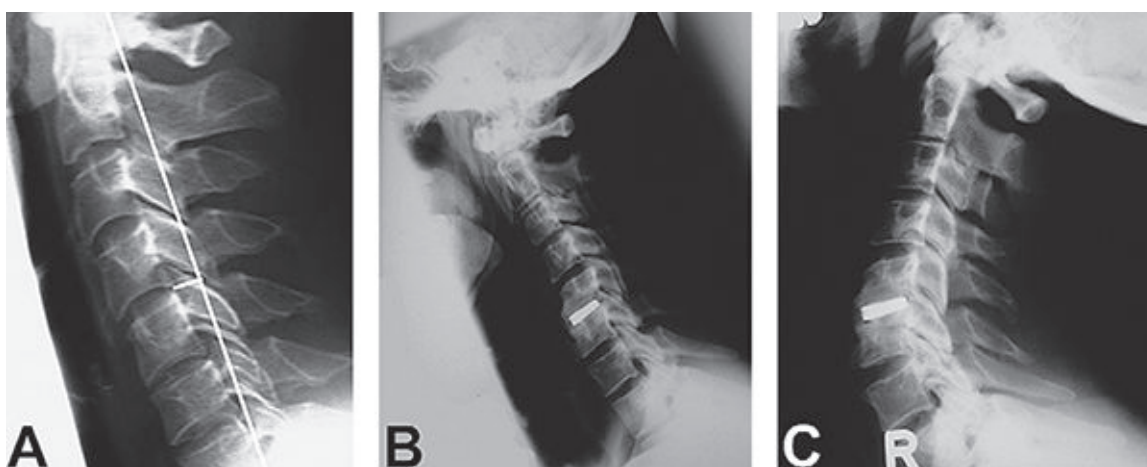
Lateral cervical spine X-ray (A) Measurement for evaluation of lordosis. (B and C) showing functional flexion/extension radiographic views at 12-month interval after anterior cervical discectomy with fusion at level C5/6 with Titanium cage. Absence of segmental motion and presence of bony bridges were documented in this patient.
